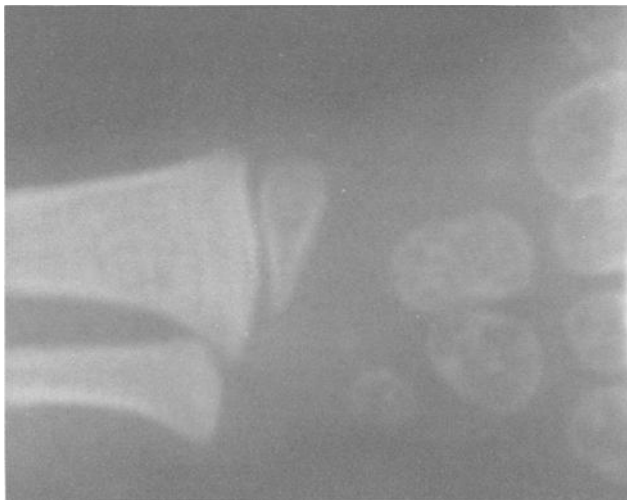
X-radiograph of the distal radius and ulna.
